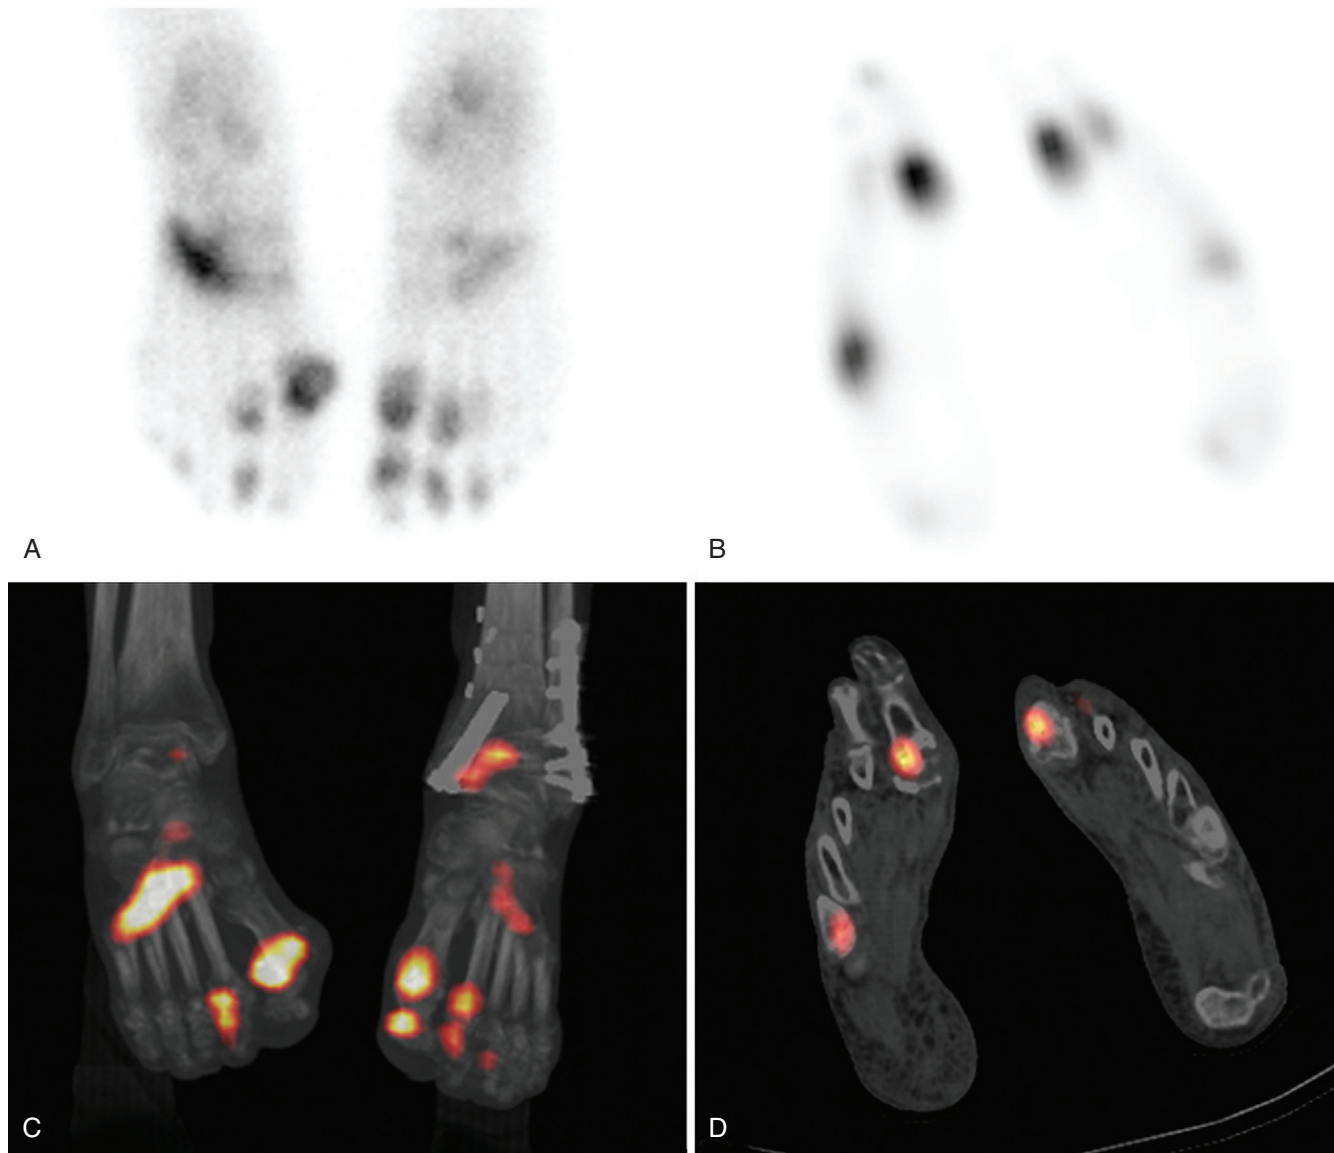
Gout (single-photon emission computed tomography [SPECT]). A 72-year-old female patient with known gout and prior trauma was investigated for possible complications. Planar (A) and transverse SPECT (B) images show multifocal increased uptake. Three-dimensional fused SPECT-CT (C) and transverse two-dimensional SPECT-CT (D) images provide superior localization of scintigraphic activity corresponding to the joints most affected by gout. (Courtesy Ho Jen, Edmonton, Canada.)
